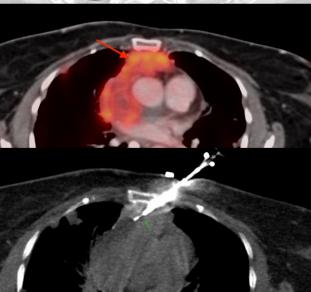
This is a 67-years old lady who was operated for a sarcomatoid thymic carcinoma. The repeat PET/CT shows recurrence of disease, with spread to the lungs, pleura and the liver. A biopsy was needed to reconfirm recurrence. In her case, an oblique left parasternal approach using an 18G coaxial biopsy gun allowed a safe biopsy, with the needle tip directed away from the vessels. The biopsy showed recurrence of disease.
